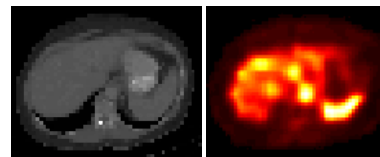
One slice of the patient attenuation map and SPECT activity distribution used as input to the Monte Carlo projector.
